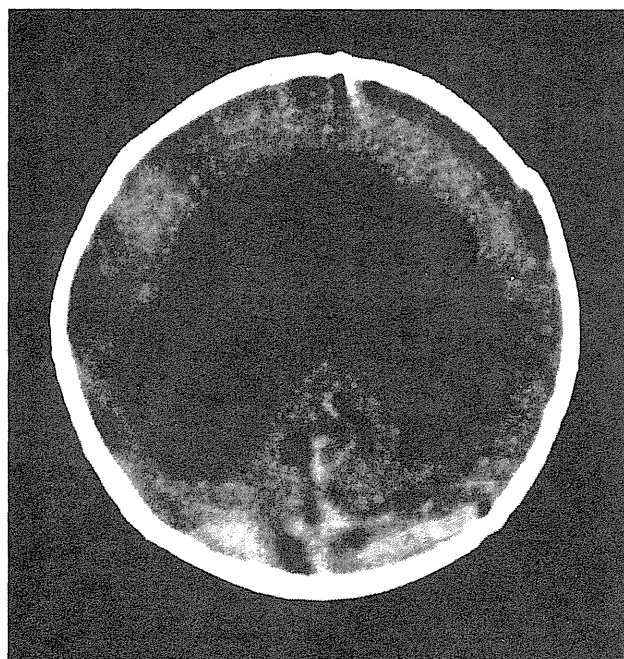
Computed tomography (CT) study of the brain. An axial CT scan obtained 8 h after birth shows separation of the hemispheres posteriorly but not anteriorly. Anterior horns of the lateral ventricles are absent. There is also an incomplete separation of the basal ganglia.
